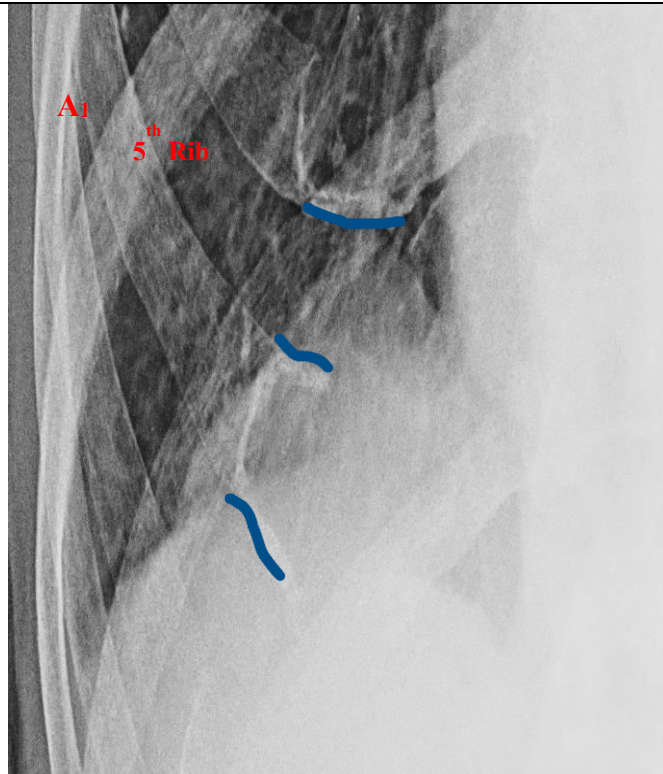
Peripheral CCC on a male radiographs (A1 & A2) and on a female radiograph(B)
